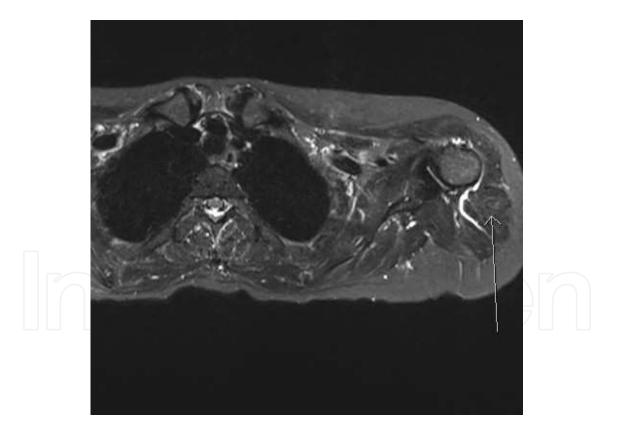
MRI right arm showed mild edema involving the right triceps muscle with minimal enhancement in the post contrast sequence in comparison to other muscles which appeared mildly atrophied.
